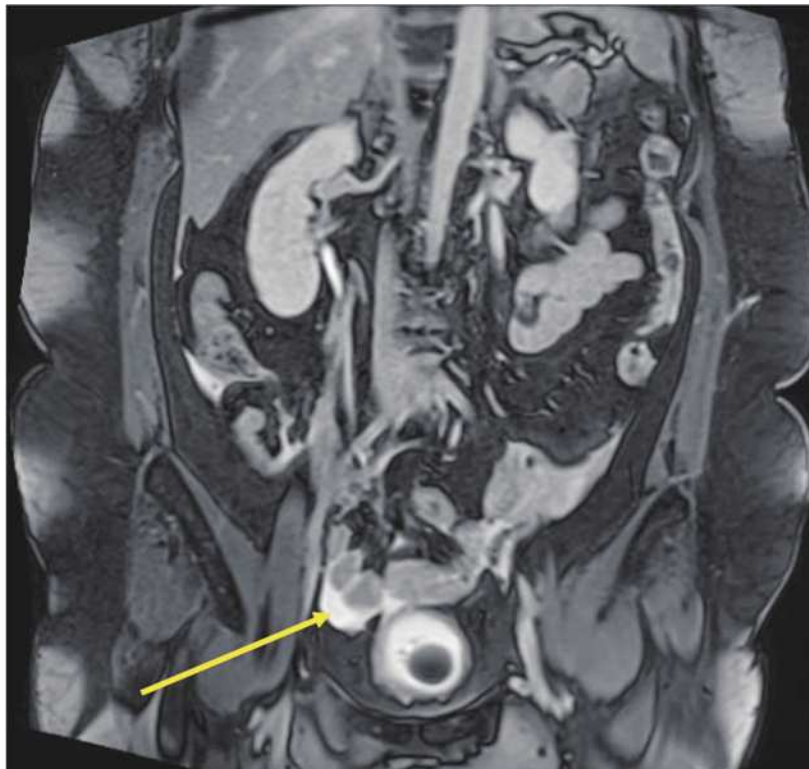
MRI of the pelvis with intravenous contrast demonstrates a small amount of ascites in the pelvic cavity. Contrast extravasation is visible adjacent to the bladder, raising suspicion of urine leakage. A Foley catheter is noted in situ. (Abbreviation: MRI: magnetic resonance imaging)
